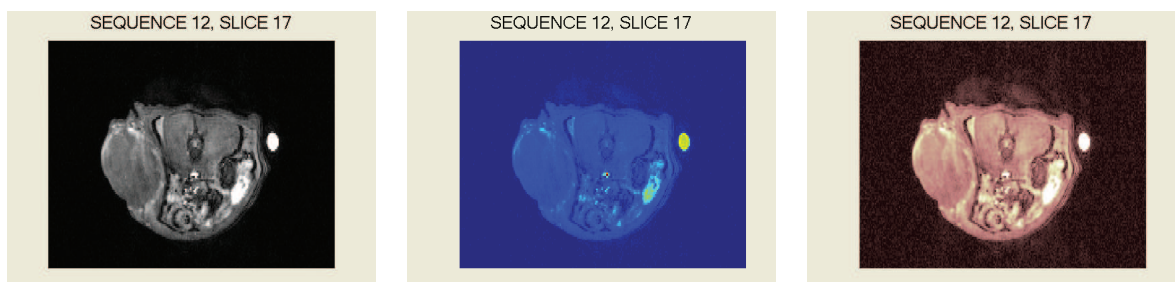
A slice of MRI data set. The leftmost image is in black and white, while the other ones are obtained by changing the color setting.
